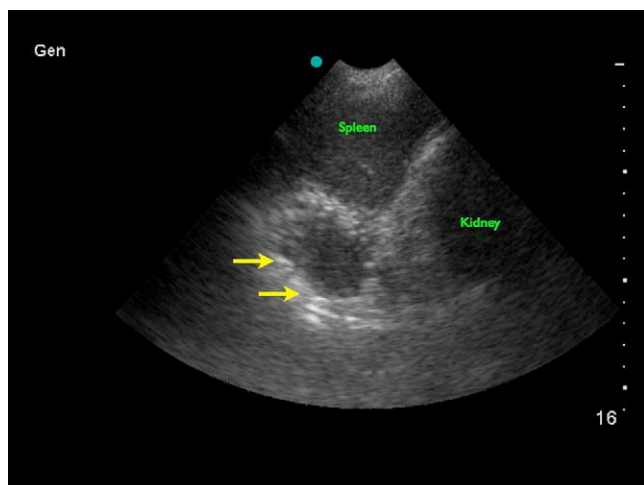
Gastric fluid ultrasound with arrow delineating round walls of gastric flexure.
